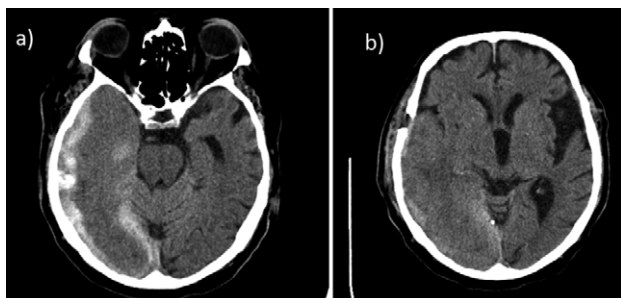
a) initial CT scan showing SDH; b) postoperative control CT scan showing regression.
